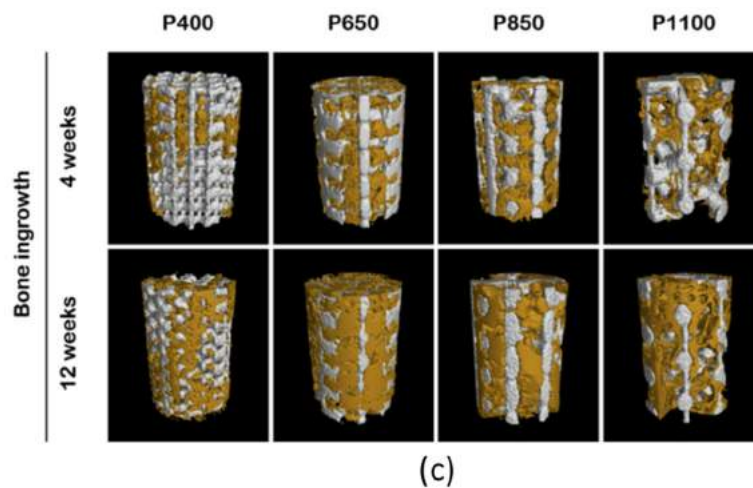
Quantitative μ -CT analysis of new bone ingrowth in the research papers of the following: (a) Chen et al. [96]; (b) Kapat et al. [92]; (c) Ouyang et al. [95].
